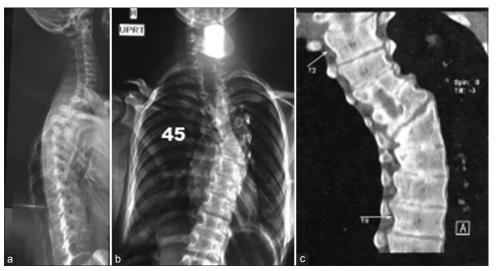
Pre-operative imaging, (a) lateral thoracic X-ray, shows normal kyphosis, (b) AP radiograph, scoliosis is 40°, (c) reconstructed coronal CT shows that an abnormal vertebra is responsible for congenital scoliosis.
